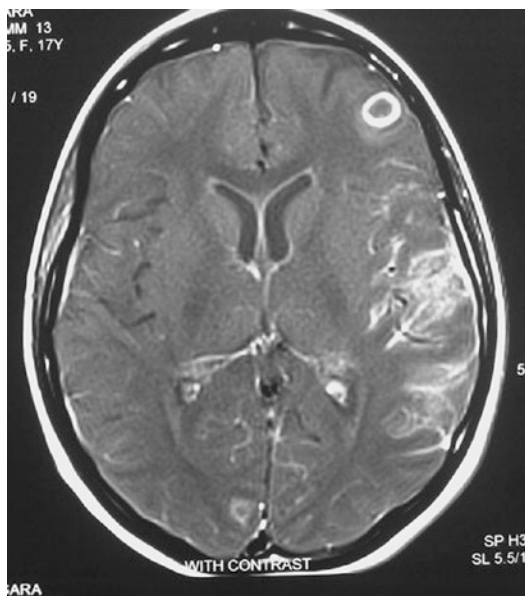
Tuberculoma with TBM. Axial post-contrast T1-weighted image through the lateral ventricles shows a tuberculoma as a cortical ring-enhancing lesion in *left* frontal lobe. There is also another small tuberculoma in *right* occipital lobe. Dural and leptomeningeal enhancements in *left* frontoparietal region indicate associated TBM
